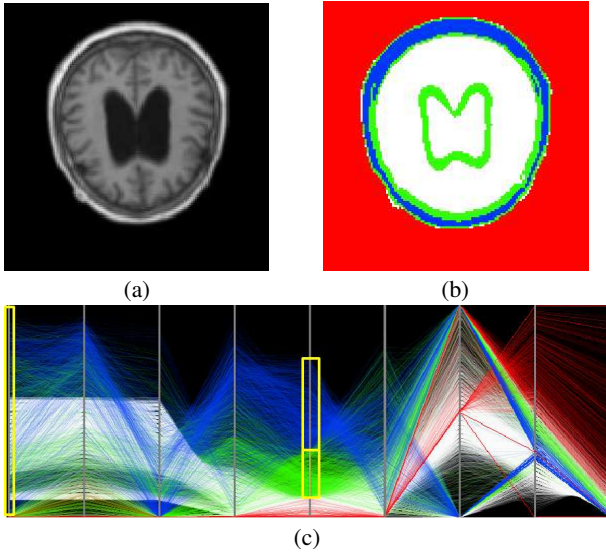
Colored slice from the *MRI head* dataset. (a) shows an original (cropped) slice, (b) shows a classification based on the intensity and 2nd order moment signatures. The *SignatureSpace* with a color band setting based on the intensity (red background; 1st framed signature axis) and 2nd order moment signatures (blue and green; 2nd yellow framed signature axis) is shown in (c).
